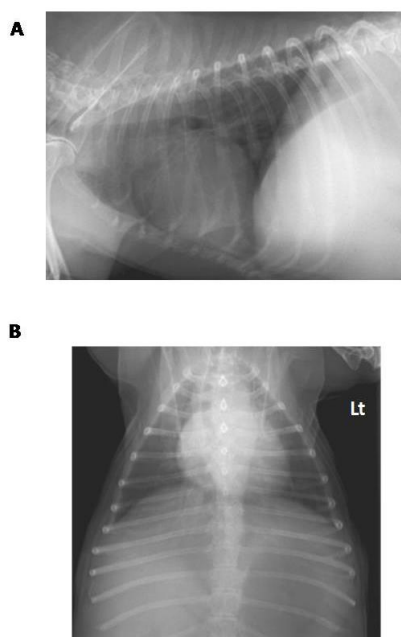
Right lateral (A) and dorso-ventral (B) thoracic radiographic findings revealed an increase in sternal contact of the cardiac silhouette and rounding of the right ventricle with clear lung fields.
